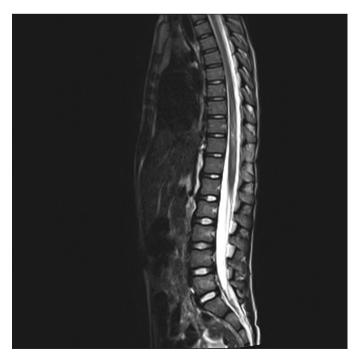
Postoperative sagittal MRI depicting complete evacuation of the mass and signs of spinal cord edema.
